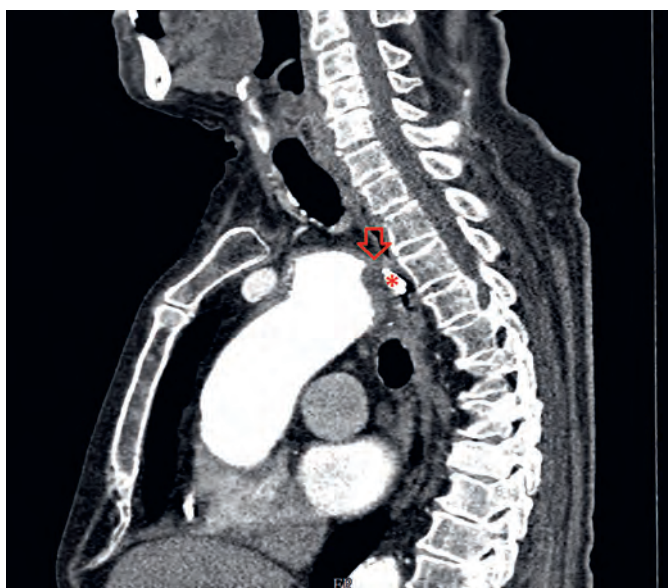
Endoscopic clip (*) identifying the level of AEF (arrow) on CTA sagittal view.
